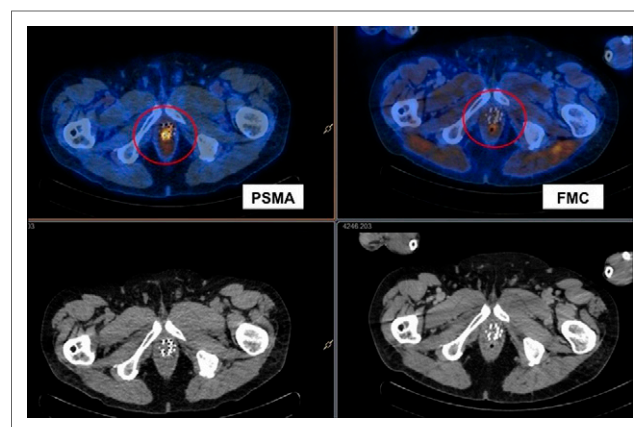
A 70-year-old man with Gleason 7 prostate cancer treated with radiation therapy who presented with rising PSA level (8.9) and PSA doubling time of 9.5 mo. ^{18}F -fluoromethylcholine (FMC) scan was negative, whereas ^{68}Ga -PSMA scan demonstrated intense uptake in prostate (maximum standardized uptake value, 4.5). Subsequent biopsy confirmed local recurrence.
